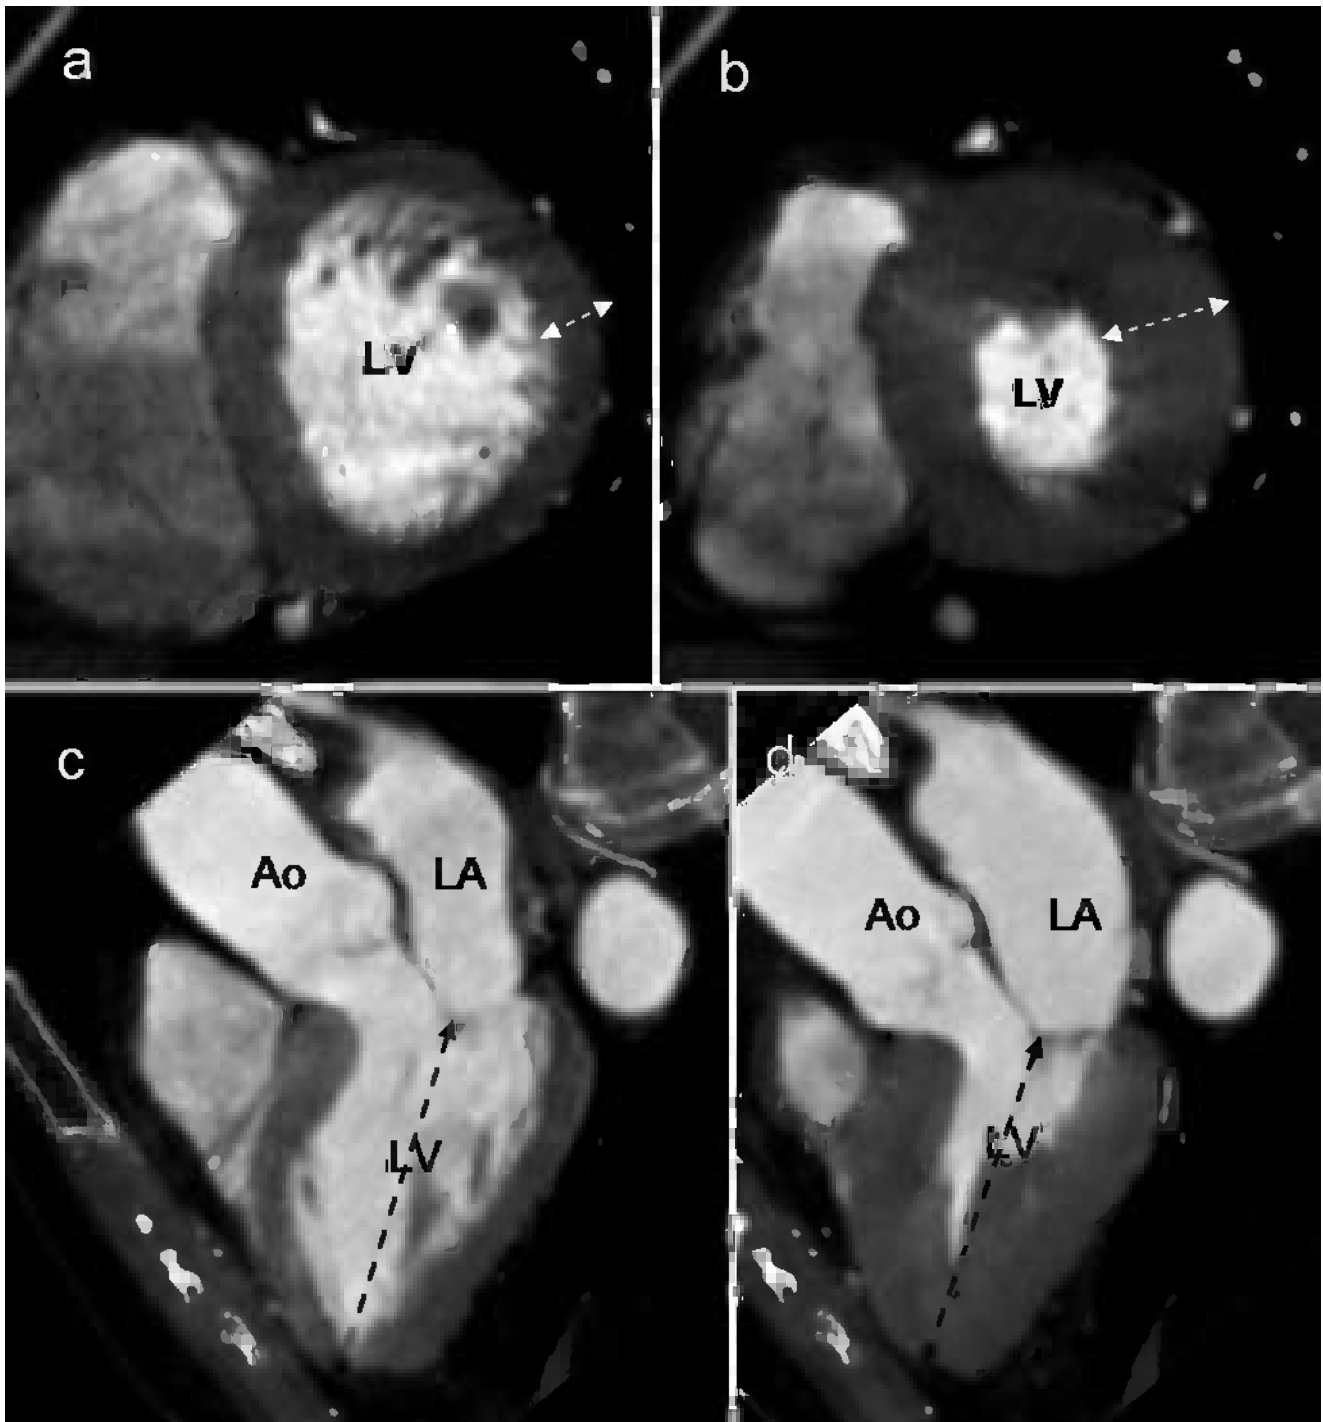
Slice images by CT showing short axis view in diastole (a) and systole (b) and long axis view in diastole (c) and systole (d). During systole, the left ventricular myocardium thickens radially (*white arrows*) and shortens longitudinally (*black arrows*)
